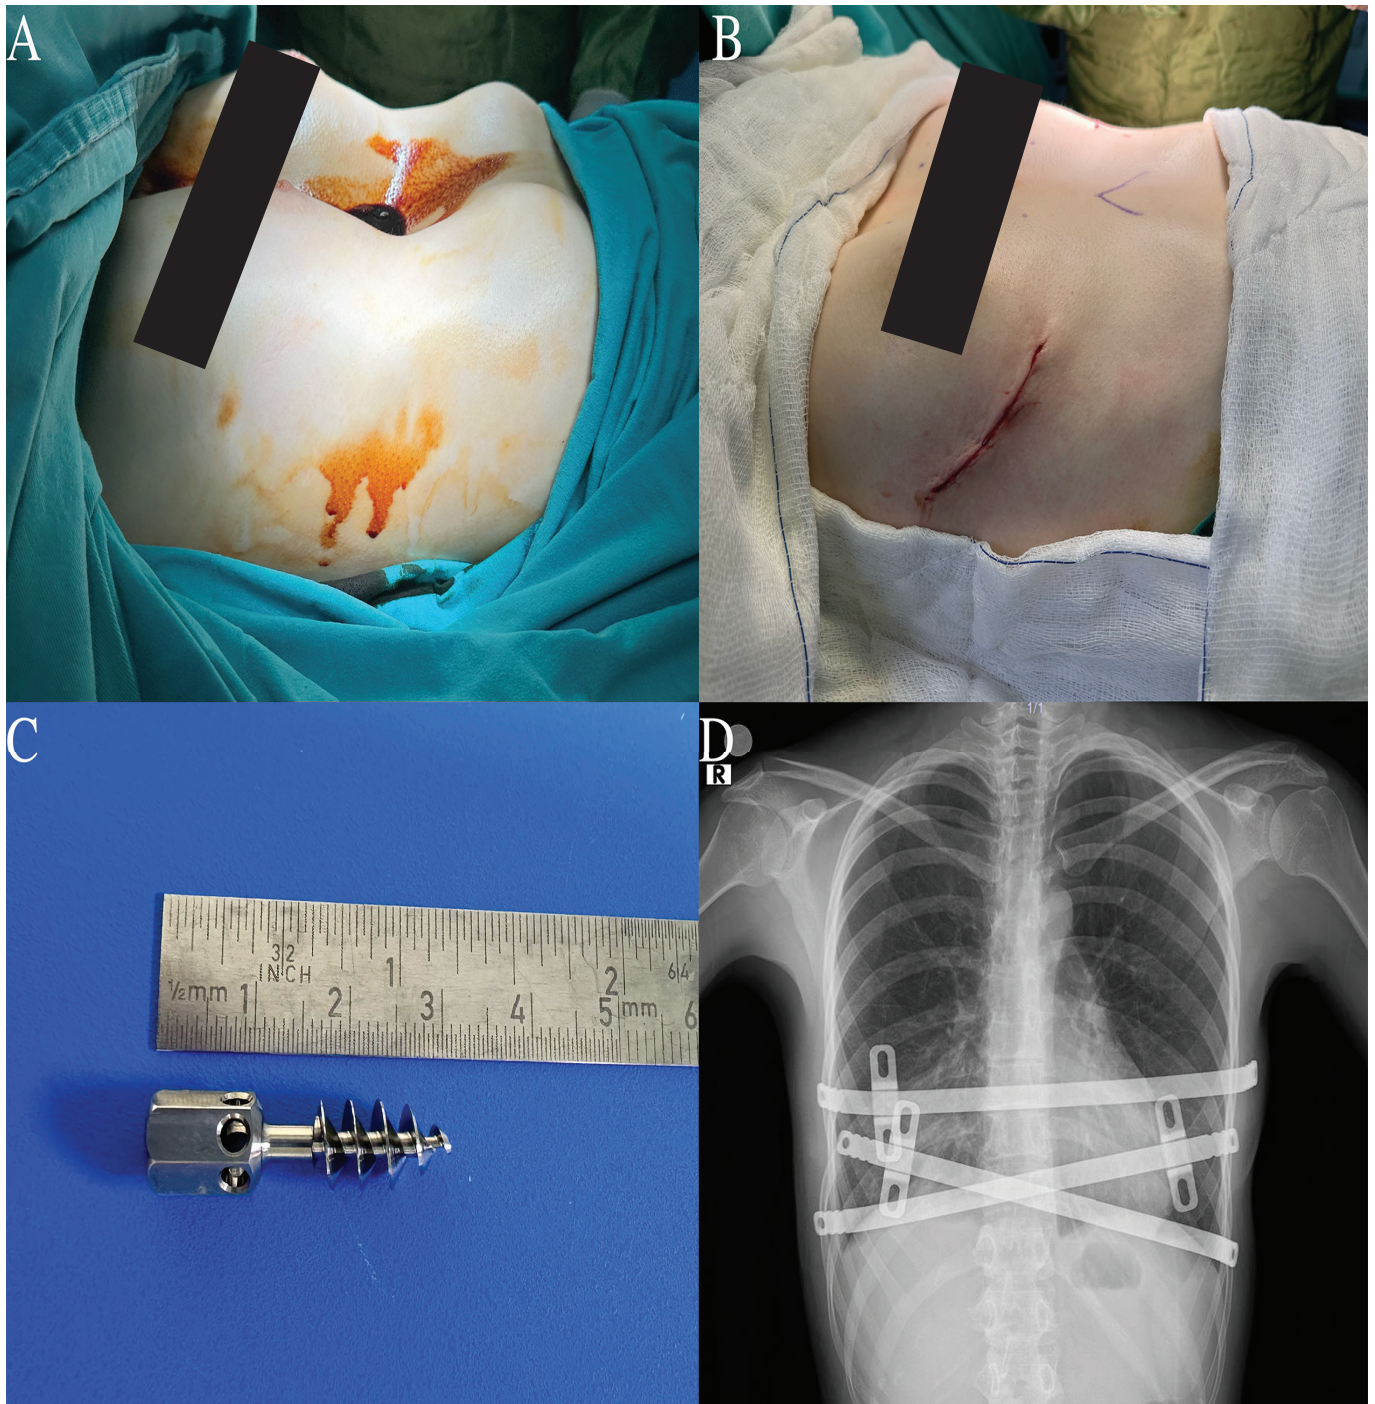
A. Patient preoperative view, B. Postoperative view of the patient. C. Park sternal elevation screw. D. Postoperative X-Ray of the patient
